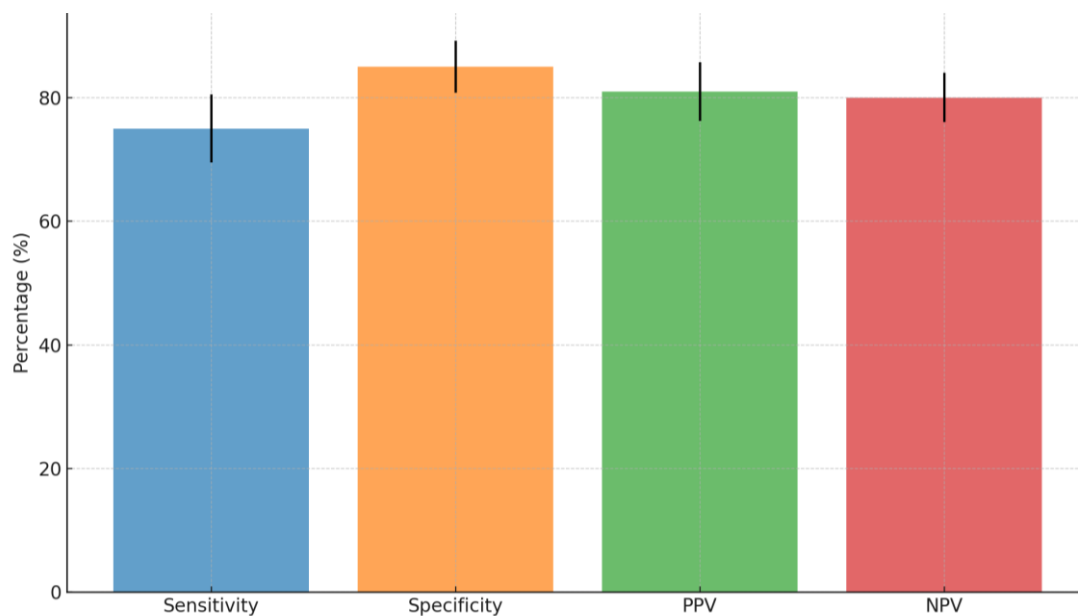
Diagnostic Accuracy -Ultrasound Imaging
